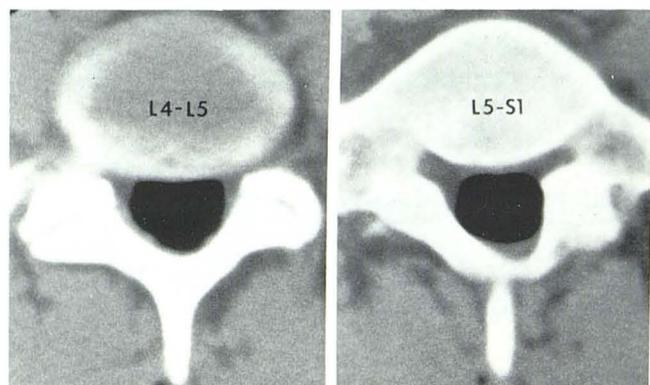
Normal case. Air CT at L4-L5 (A) and L5-S1 (B) disk levels. Air fills subarachnoid space and abuts posterior margins of disks. Root sleeves are not visualized.
